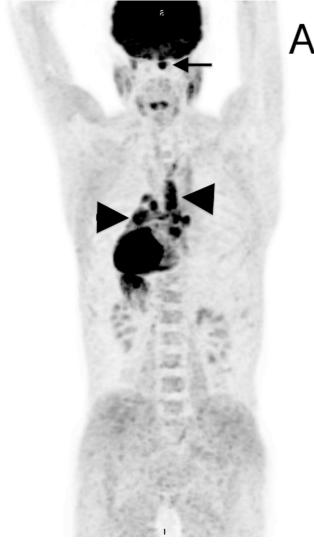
A. PET/CT images were obtained 60 minutes after intravenous injection of 10 mCi (370 MBq) of ¹⁸F-FDG. Maximum intensity projection (MIP) image show intense FDG uptake in the nasopharynx (arrow) and thorax (arrowhead).
